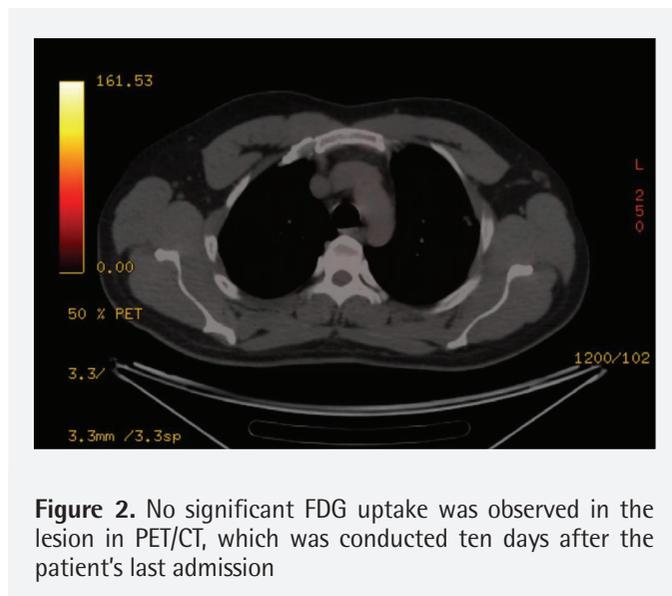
No significant FDG uptake was observed in the lesion in PET/CT, which was conducted ten days after the patient's last admission
